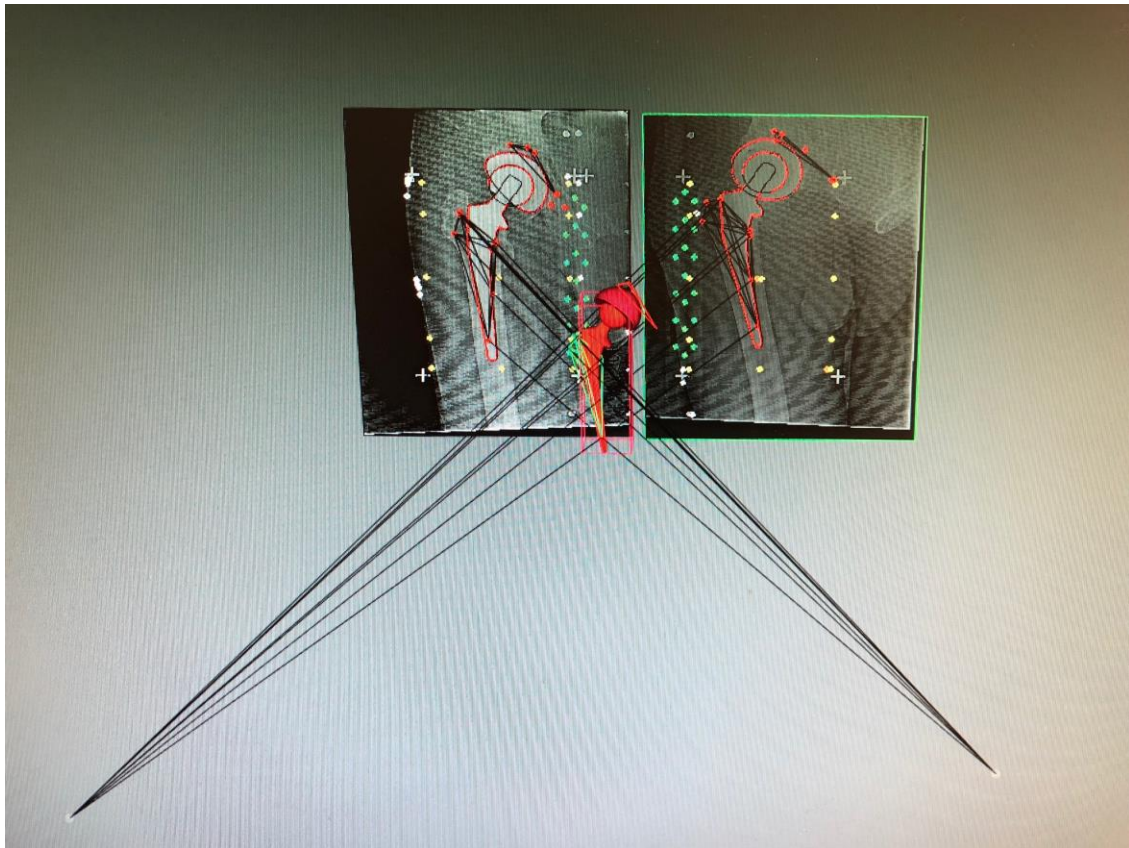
RSA Software digitally projecting prosthesis position based on RSA radiographs
